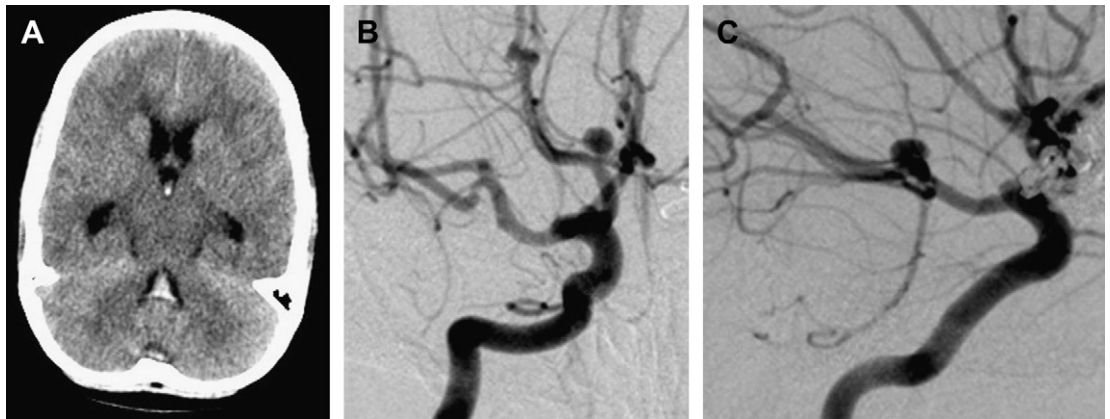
Saccular aneurysm. A 17-year-old girl with Majewsky type II osteodysplastic dwarfism presented with headache. Subarachnoid and intraventricular hemorrhage was demonstrated on nonenhanced CT ([A](#)). Initial diagnostic catheter angiography demonstrated 10 saccular intracranial aneurysms, the majority and largest of which were associated with the left anterior circulation. The patient underwent a left pterional craniotomy with clipping of multiple aneurysms. A saccular right P1/P2 posterior cerebral artery (PCA) aneurysm, filling via a near-fetal PCA on anteroposterior (AP) ([B](#)) and lateral ([C](#)) right ICA angiograms, underwent endovascular coiling during the same admission.
